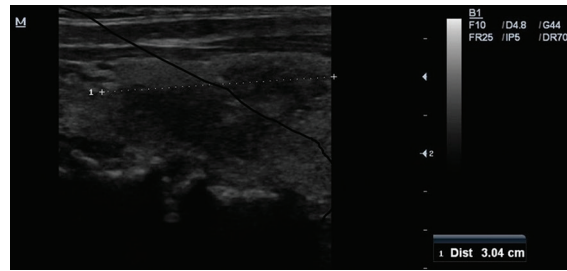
Preoperative ultrasound showing a heterogeneous nodule of approximately 3 cm in the left thyroid lobe.
